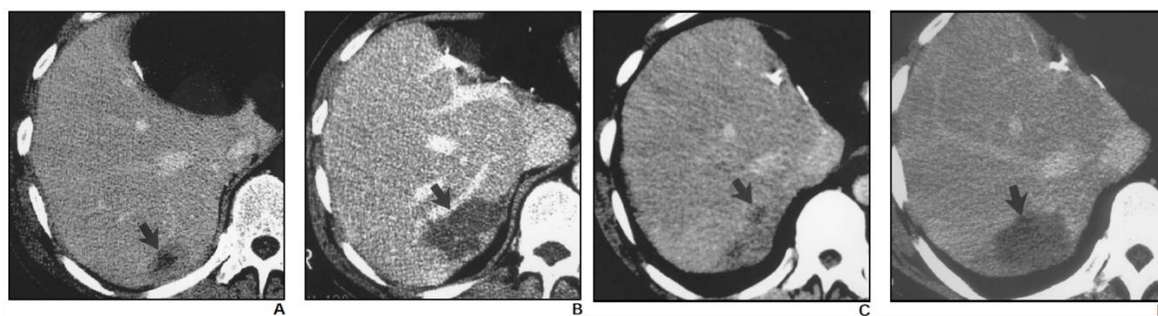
CT scans from a 46-year old patient with metastatic colon cancer. A: Before the treatment a 3-cm metastasis is observed in the posterior right lobe of the liver. B: Immediately after the ablation a thermal injury is observed in the treated area and there is no evidence of residual tumor. C: Follow-up 3 months after ablation shows recurrent tumor in the margins of the ablated area. D: Immediately after re-ablation, it is possible to observe an enlarged thermal injury with no evidence of recurrent tumor [12].
